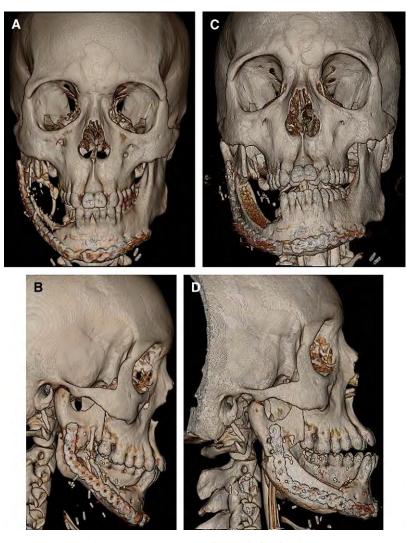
(A-D) CT scan before and after flap inset.
